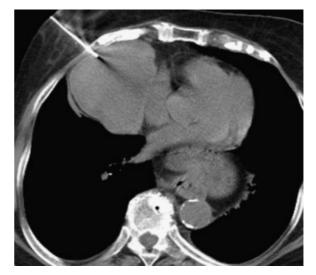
Axial chest CT without contrast showing percutaneous biopsy of the low-density region of the right chest mass.
